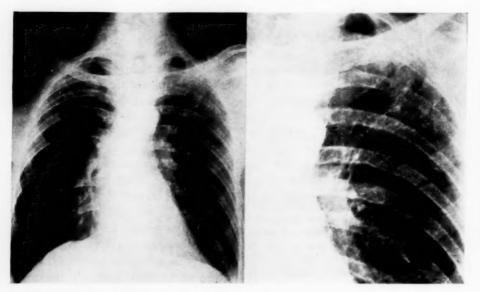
Early, active, fan-shaped lesion in left upper lobe; b, close-up of roentgenogram a for clearer depiction of lesion.
